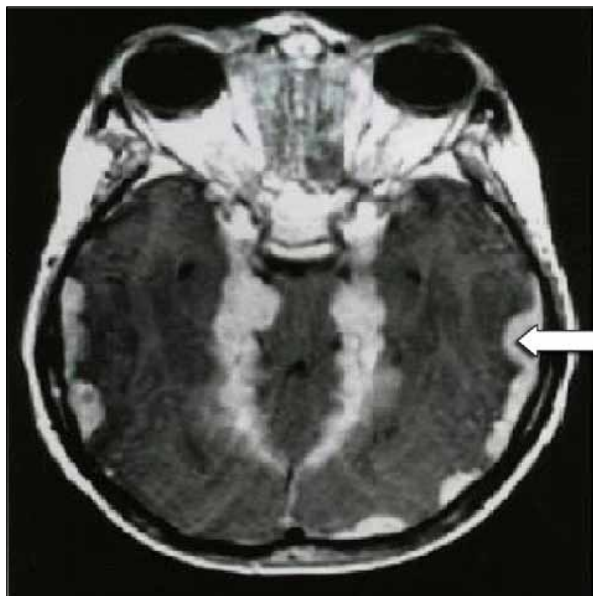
Postcontrast, T1-weighted, axial magnetic resonance imaging showing diffuse meningeal infiltration (arrow).
